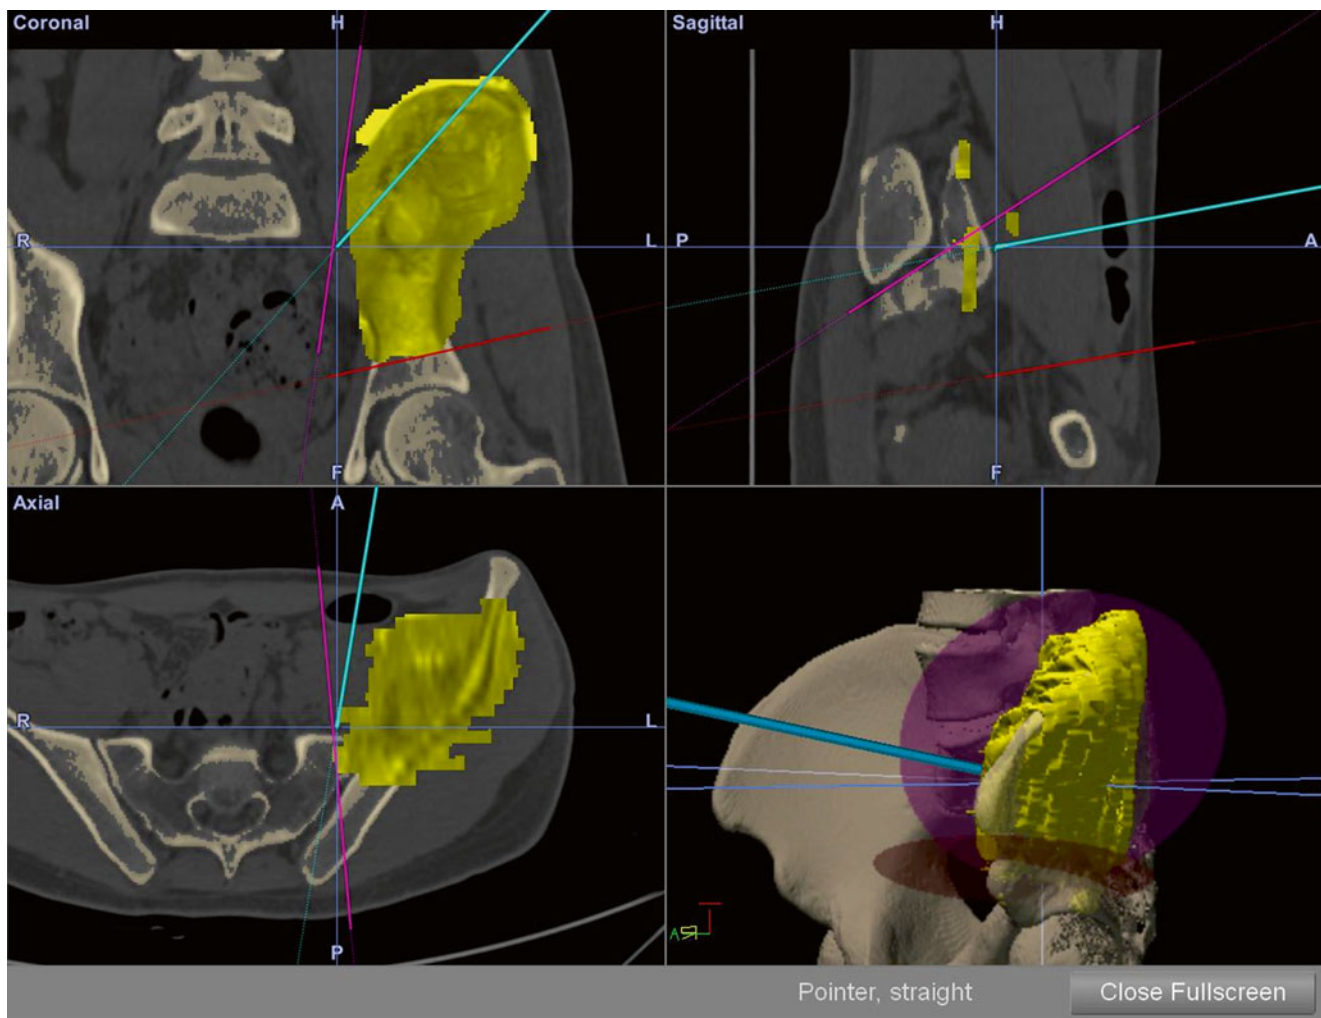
Screen shot from intraoperative resection of a pelvic sarcoma using computer navigation. The intended resection (*yellow*) is planned from both preoperative MRI and CT scans. The planes of resection have been identified and marked (*red and purple lines*). The
